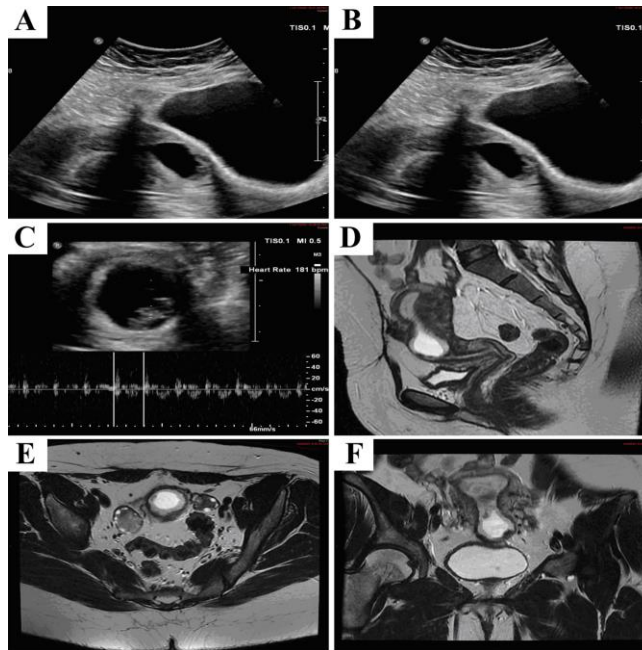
A and B; the pelvic US shows the abnormal location of the sac at CS scar intrauterine gestational sac with empty fundal endometrial cavity and endocervical canal. C; viable fetal pole with 153 beats per minute fetal heart rate. D; Sagittal and E; coronal T2WI MRI was done for confirmation of CSP with significant thinning of anterior myometrium.
